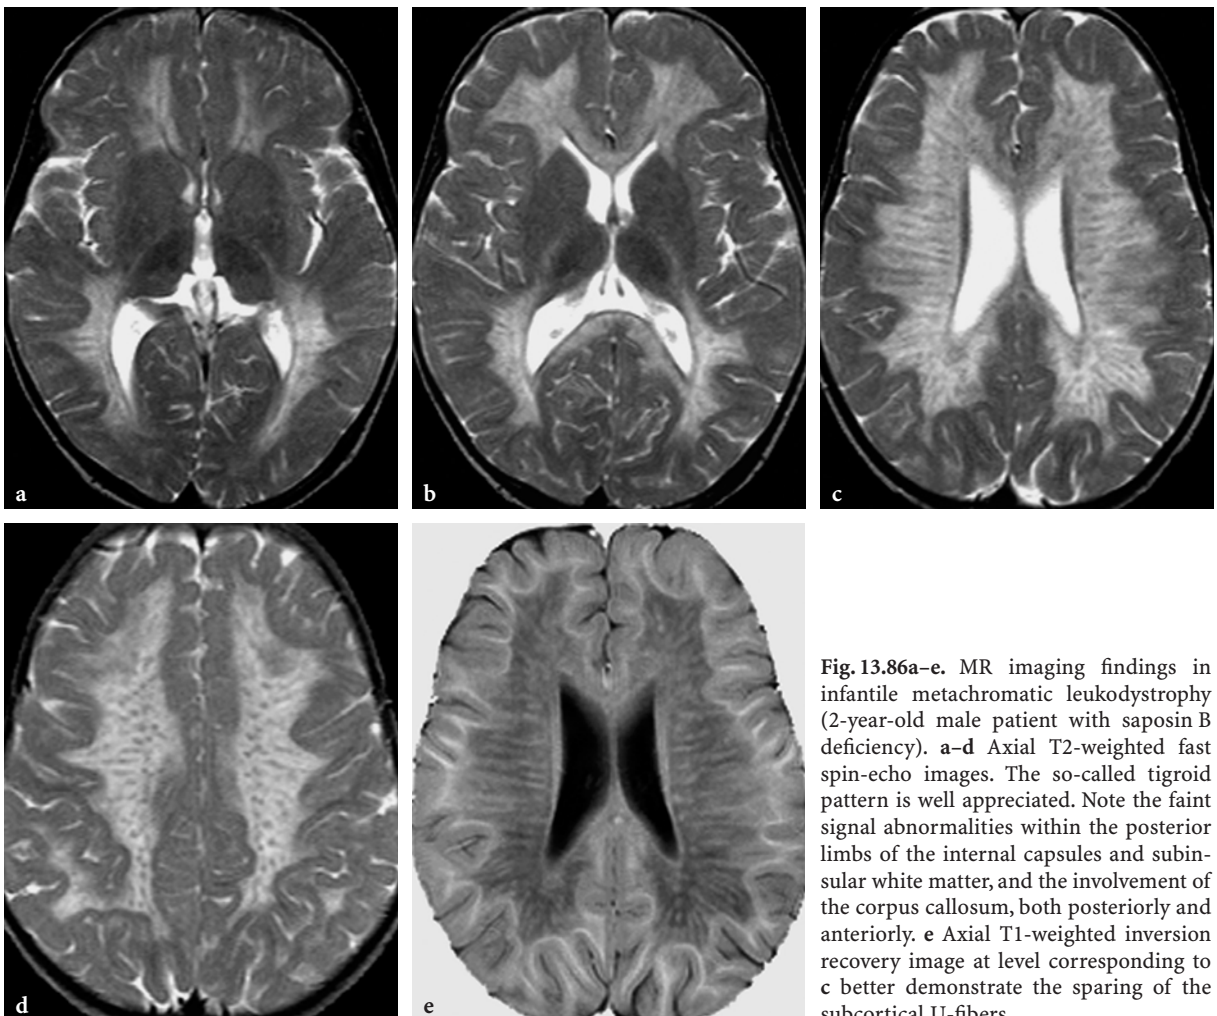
MR imaging findings in infantile metachromatic leukodystrophy (2-year-old male patient with saposin B deficiency). a–d Axial T2-weighted fast spin-echo images. The so-called tigroid pattern is well appreciated. Note the faint signal abnormalities within the posterior limbs of the internal capsules and subinsular white matter, and the involvement of the corpus callosum, both posteriorly and anteriorly. e Axial T1-weighted inversion recovery image at level corresponding to c better demonstrate the sparing of the subcortical U-fibers
